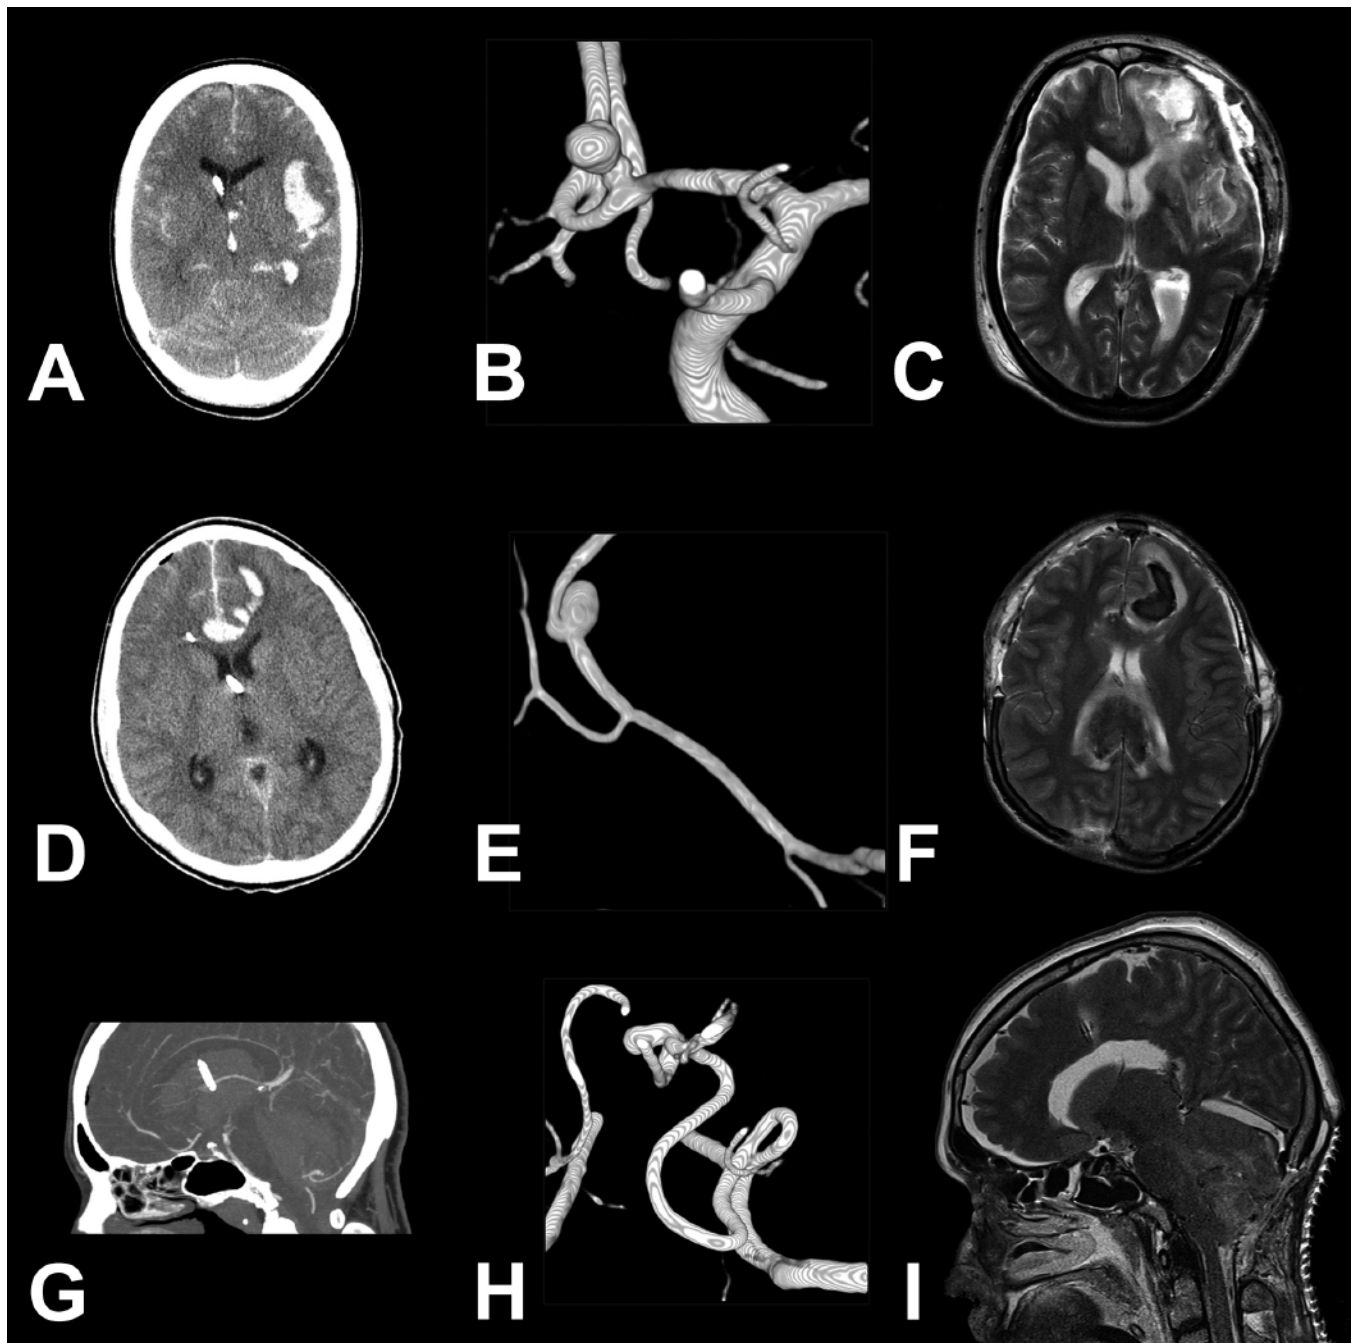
Modalities of DC. Computed tomography scans showing SAH and ICH caused by ACoA (A), pericallosal artery (D), and PICA aneurysms (G); the causative lesions can be seen on digital subtraction angiograms (B, E, and H, respectively). Magnetic resonance images obtained after DHC (C), bifrontal craniectomy (F), and suboccipital craniectomy (I) for intractably elevated ICP, demonstrating the extent of injury caused by SAH and the decompression achieved by DC.
